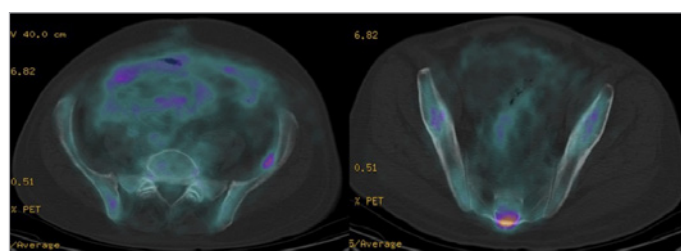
Bone involvement by PET-CT in Erdheim-Chester disease (III).
